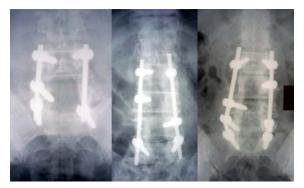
The anteroposterior x-ray film of lumbar spine showed the partial pedicular screwing in interbetween vertebra of the fusion segment
